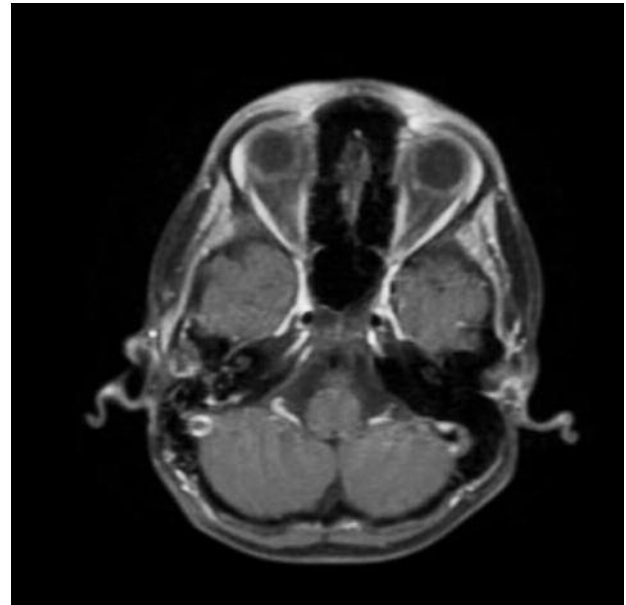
Follow-up axial contrast-enhanced fat-suppressed axial T1-weighted image shows marked regression of enhancement of mastoid cells
